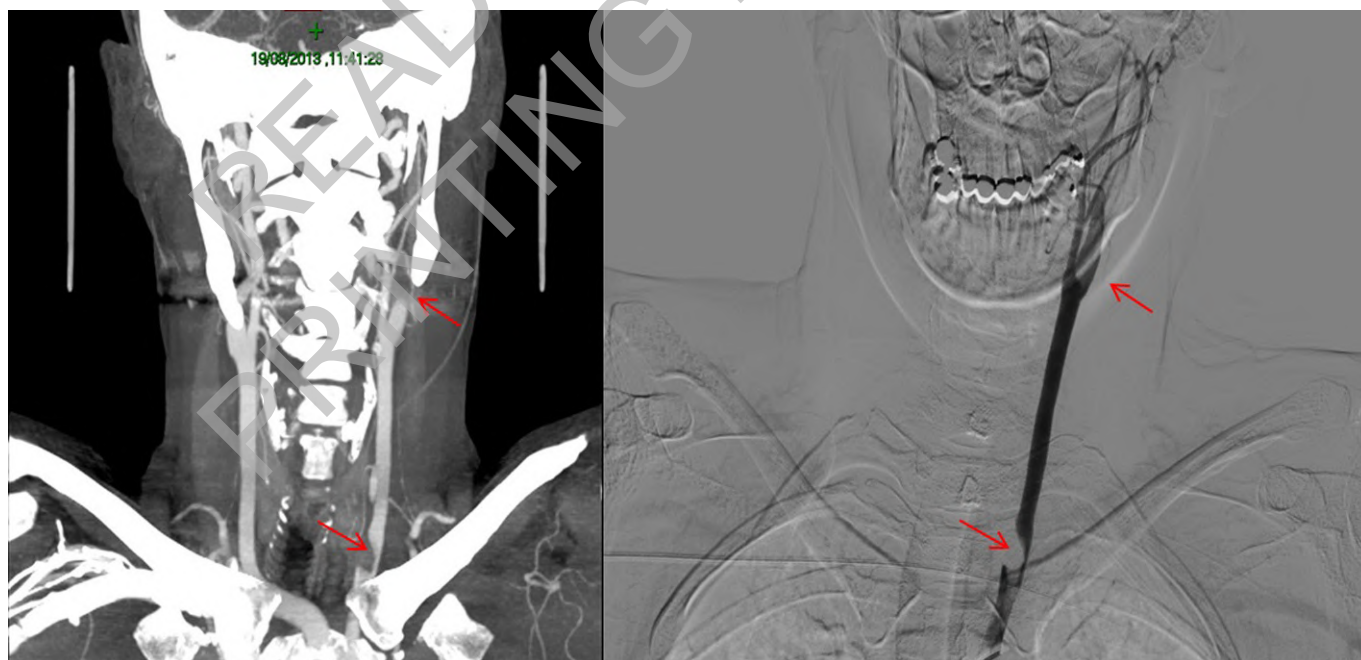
Lesion of the left common carotid. a. The CT scan showed left internal carotid occlusion at 1 cm from the bifurcation. b. Carotid angiography confirmed pre-occlusive stenosis at 2 cm from the origin of the common carotid artery, with a downstream stop by the opacity of the proximal internal carotid artery.
